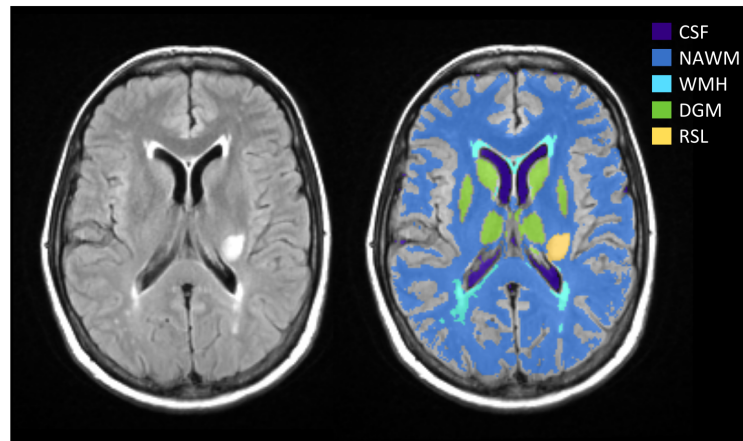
Representative MRI data and tissue segmentation. FLAIR image (left) and tissue masks superimposed on FLAIR image. Reprinted from Heye et al. (2016a).
